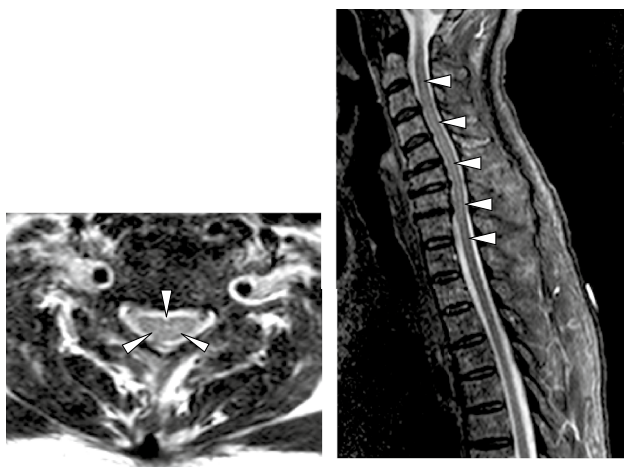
Spinal magnetic resonance imaging of case 2. High signal intensity was detected on short TI inversion recovery (STIR) images around the central canal at spinal cord positions coinciding with the dermatomes where pain was experienced
